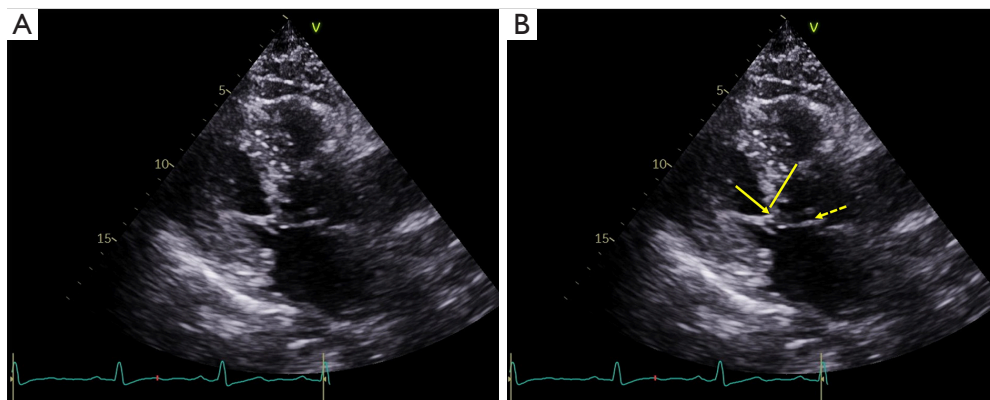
Severe SAM of the mitral valve. (A) A late-systolic parasternal long-axis view of severe mitral valve SAM in a patient with hypertrophic cardiomyopathy and discrete upper septal thickening (sigmoid septum morphology); (B) findings in panel B include marked basal septal systolic thickening (solid line), SAM with anterior mitral leaflet-septal contact (solid arrow), and systolic obliteration of the left ventricular outflow tract (dashed arrow). SAM, systolic anterior motion.
